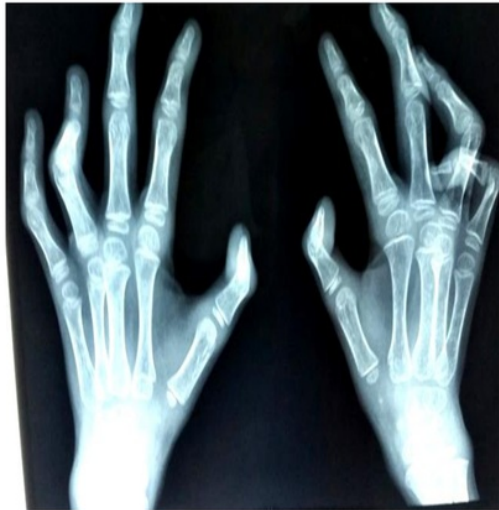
X-ray hands showing B/L camptodactyly
